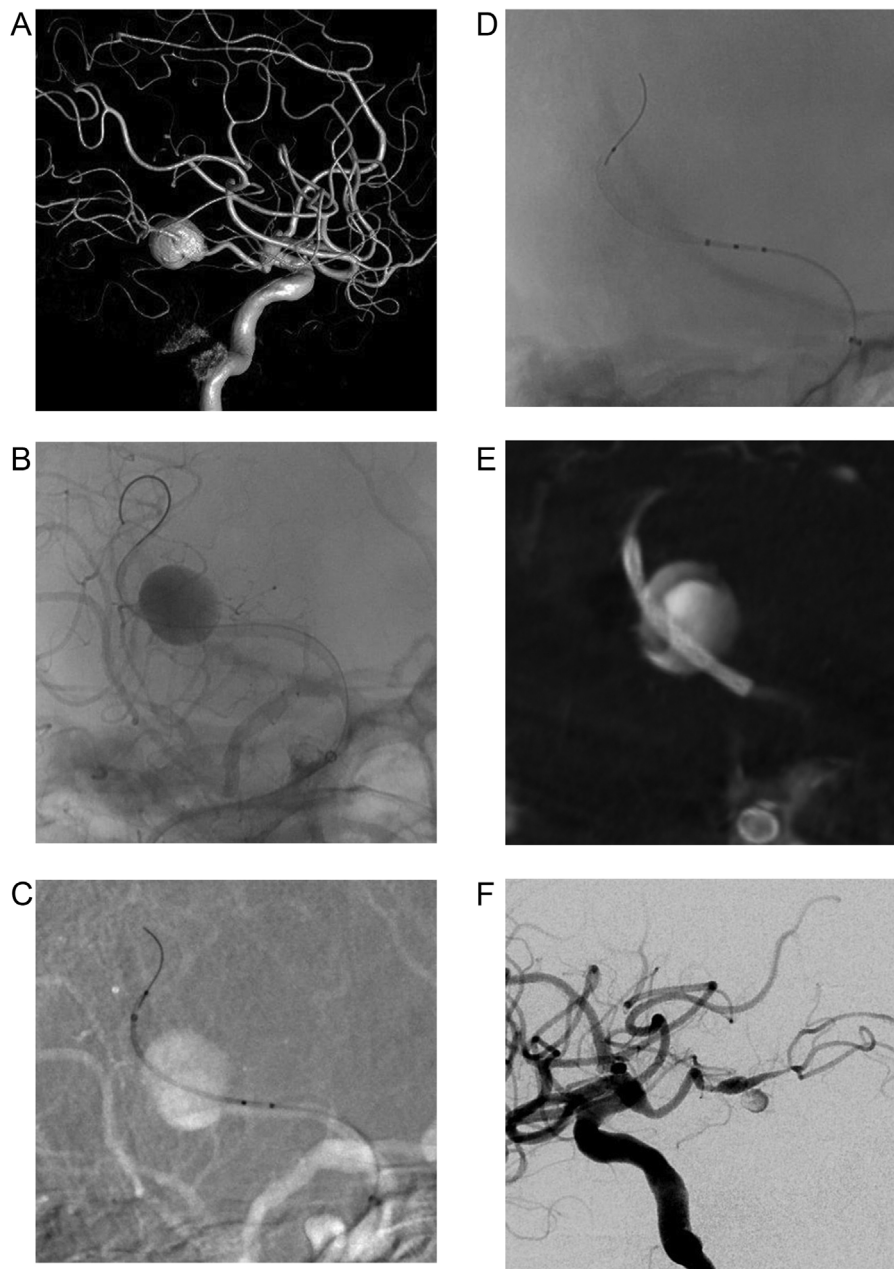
Pat no. 23 with in-stent stenosis and distal stent tapering. This patient presented with an asymptomatic left carotid ophthalmic aneurysm that was treated with a single Surpass Evolve  $4.5 \times 17$  mm. (A) Subtracted selective left internal carotid angiography, (B) unsubtracted selective left internal carotid angiography and (C) radiographic image obtained immediately after the intervention shows an adequately implanted device across the aneurysm neck with optimal stent wall apposition. (D) Subtracted, (E) unsubtracted and (F) radiographic images obtained at the six-month follow-up show mild in-stent stenosis and significant distal end tapering of the stent.
